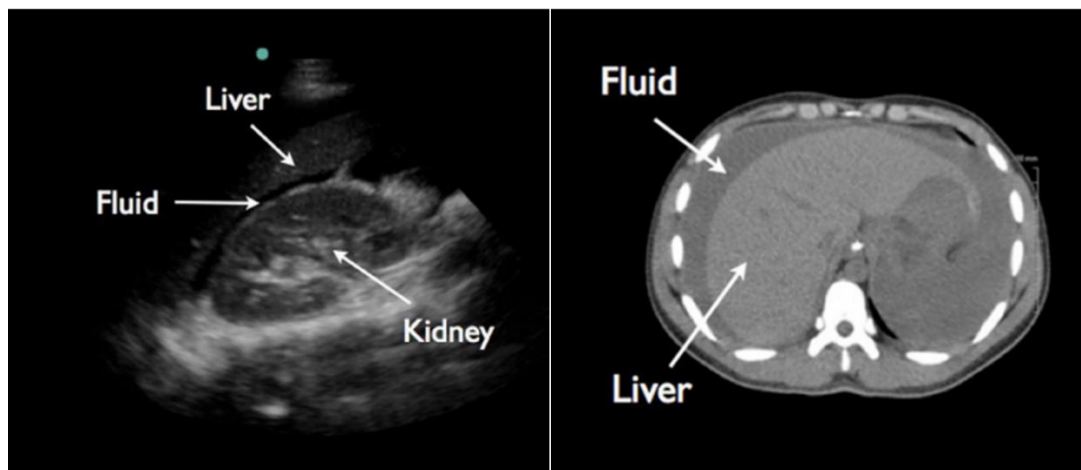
Comparison of a FAST scan (to the left) and a CT scan (to the right) of the same patient [14].
